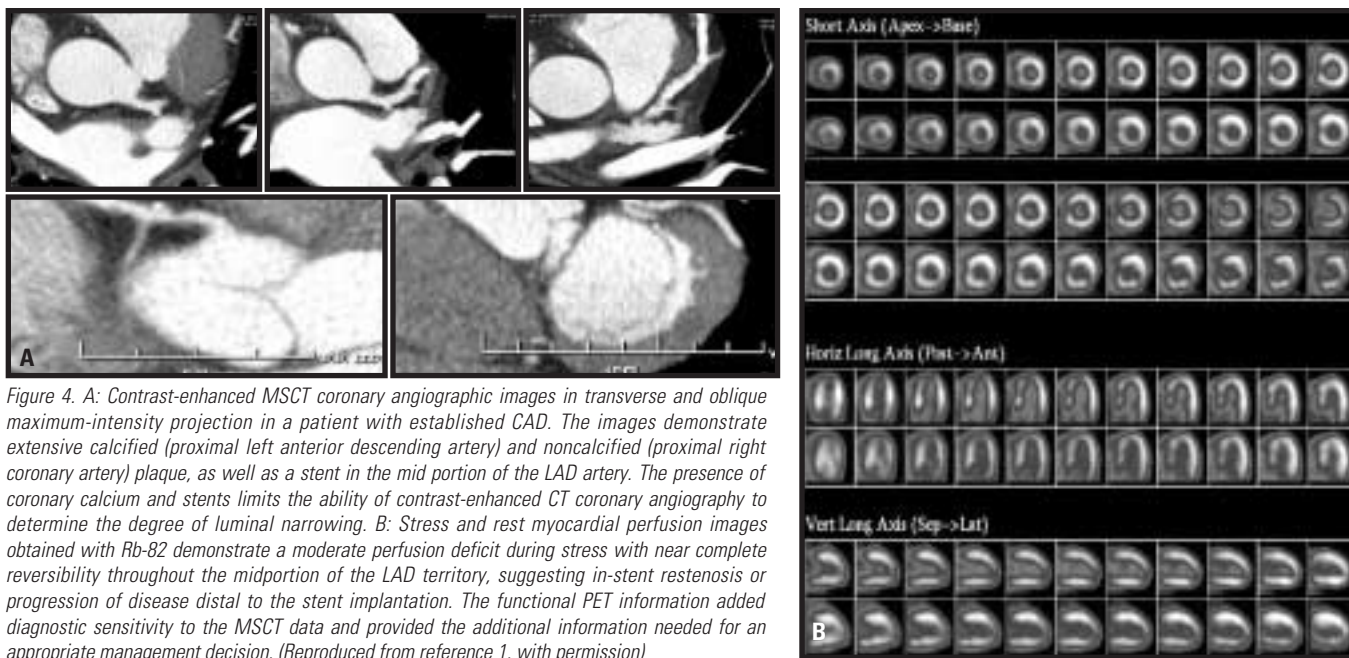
A: Contrast-enhanced MSCT coronary angiographic images in transverse and oblique maximum-intensity projection in a patient with established CAD. The images demonstrate extensive calcified (proximal left anterior descending artery) and noncalcified (proximal right coronary artery) plaque, as well as a stent in the mid portion of the LAD artery. The presence of coronary calcium and stents limits the ability of contrast-enhanced CT coronary angiography to determine the degree of luminal narrowing. B: Stress and rest myocardial perfusion images obtained with Rb-82 demonstrate a moderate perfusion deficit during stress with near complete reversibility throughout the midportion of the LAD territory, suggesting in-stent restenosis or progression of disease distal to the stent implantation. The functional PET information added diagnostic sensitivity to the MSCT data and provided the additional information needed for an appropriate management decision. (Reproduced from reference 1, with permission)
